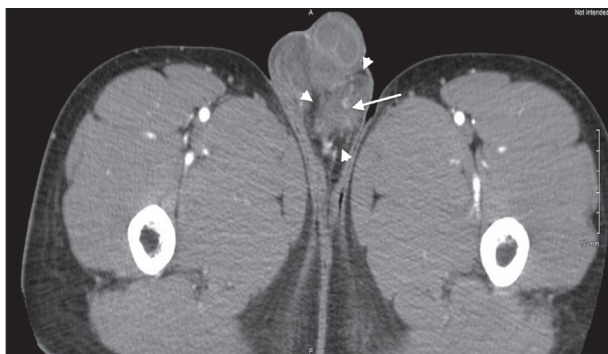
Computed tomography of the pelvis demonstrating irregular appearance and hypodense foci in patchy distribution (white arrowheads) around the partially visualized left testis (white arrow) demonstrating likely inflammation.
